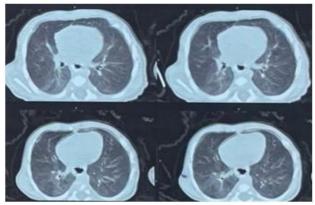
HRCT Chest of case 2-showing subtle areas of Ground Glass Opacities (GGOs) in the dependent portion of bilateral lower lobes (right>left)
